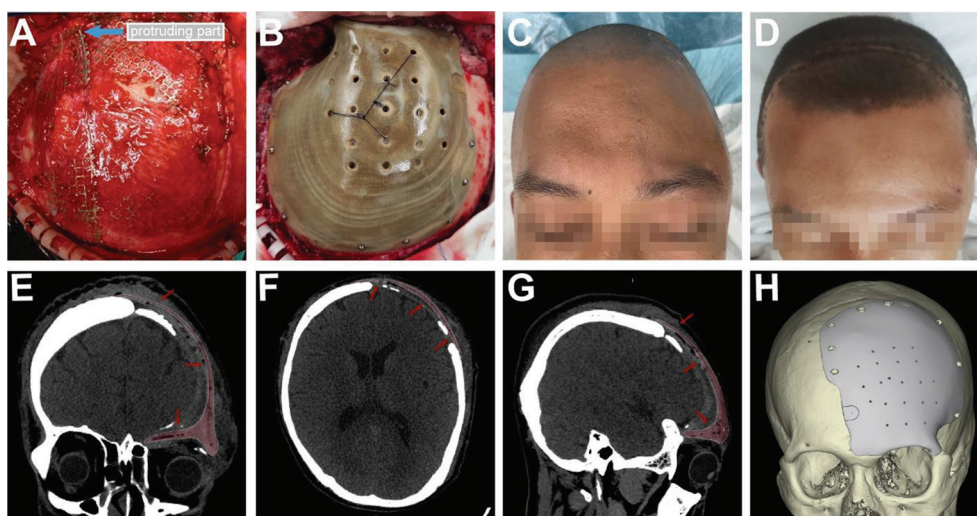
Clinical implantation and postoperative effect of FFF-fabricated PEEK skull prosthesis. (A,B) During the operation, the titanium was replaced with an FFF-fabricated PEEK skull implant. The protruding part of the titanium could be observed (blue arrow) and was resolved after switching to the PEEK implant, and the PEEK implant was fixed to the skull using titanium nails. (C,D) The appearance of the patient's forehead before (C) and after (D) the implantation of PEEK skull prosthesis. (E–H) A follow-up 3D reconstruction of the head CT after the cranioplasty reveals the positional relationship between the FFF-printed PEEK skull implant and the skull defects. The PEEK implant is indicated by red arrows.
